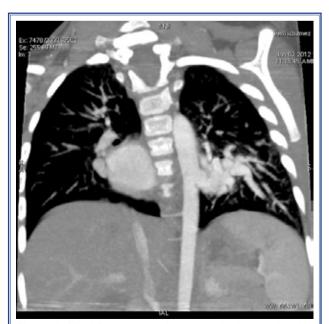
Multislice computed tomography image showing an arteriovenous fistula arising from the descending aorta.
